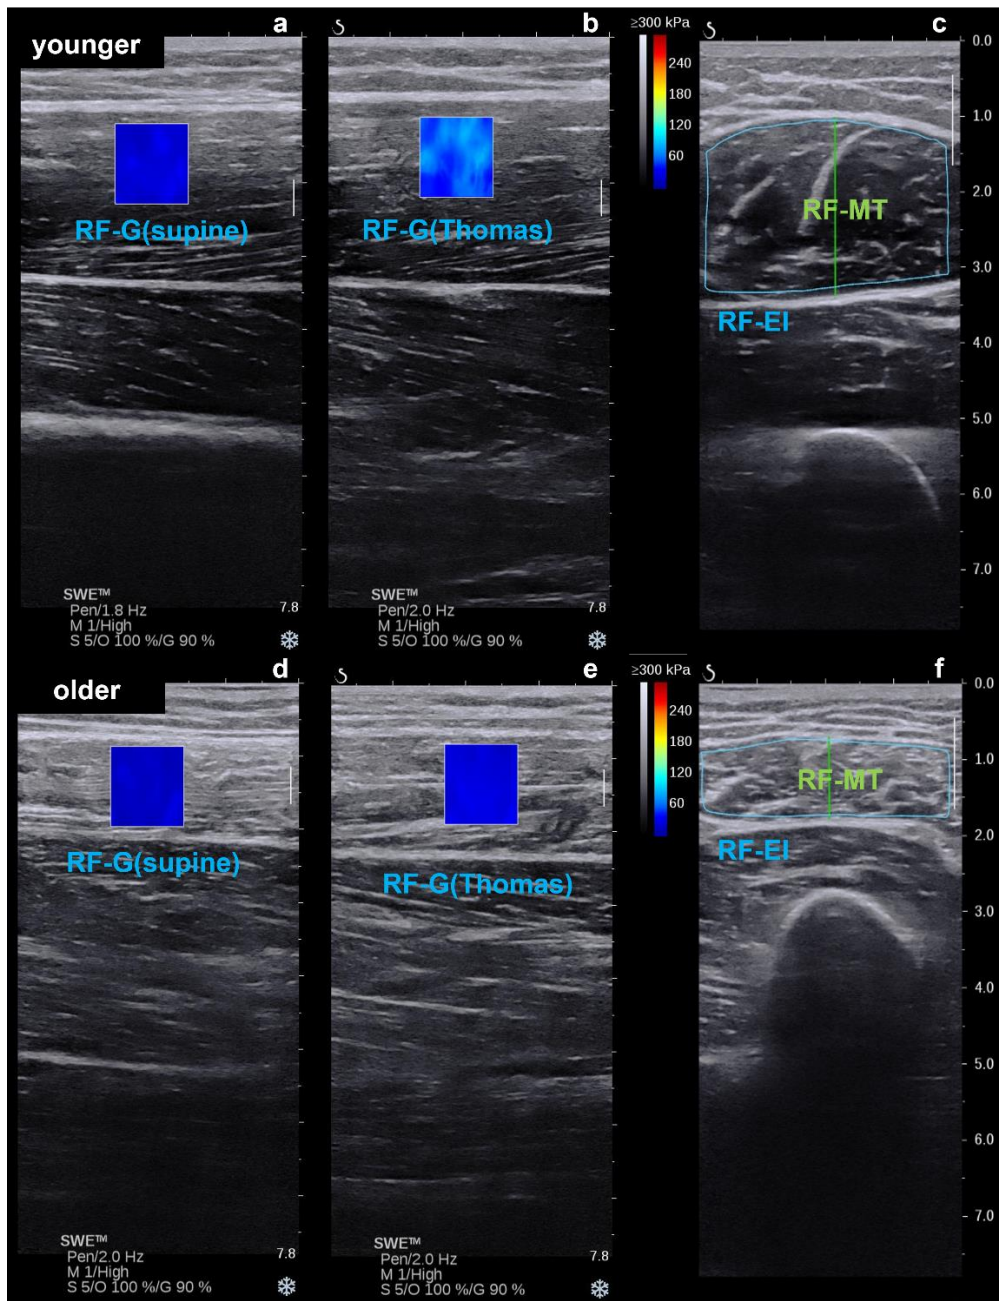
Example ultrasound images
